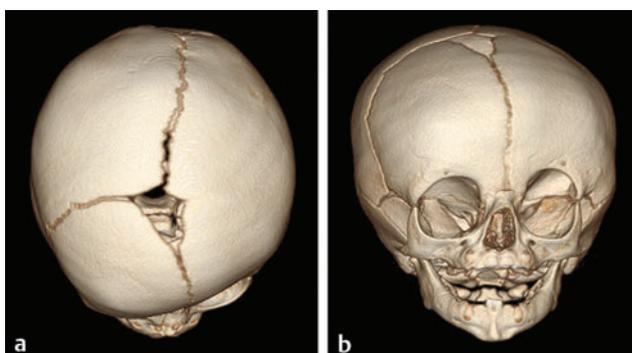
Three-dimensional CT scans in a case of unilateral coronal synostosis showing in exquisite detail both (a) sutural closure and (b) facial deformity.
